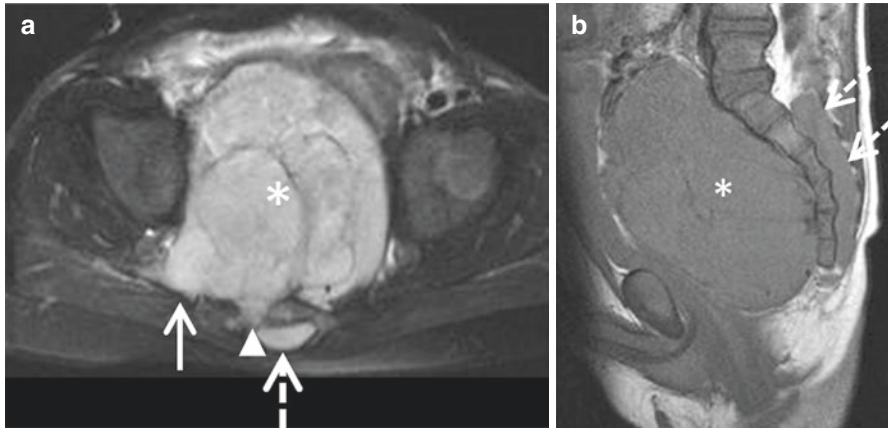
A 1-year-old boy pelvic with presacral neuroblastoma. MR transverse FS T2-weighted (a) and sagittal T1-weighted (b) sequences show the tumor (asterisks) invading the sacral holes (arrowhead) and dural cul-de-sac (dotted arrows) (not an IDRF). Tumor extends into the gluteal region (arrow) through greater sciatic foramen (IDRF)
